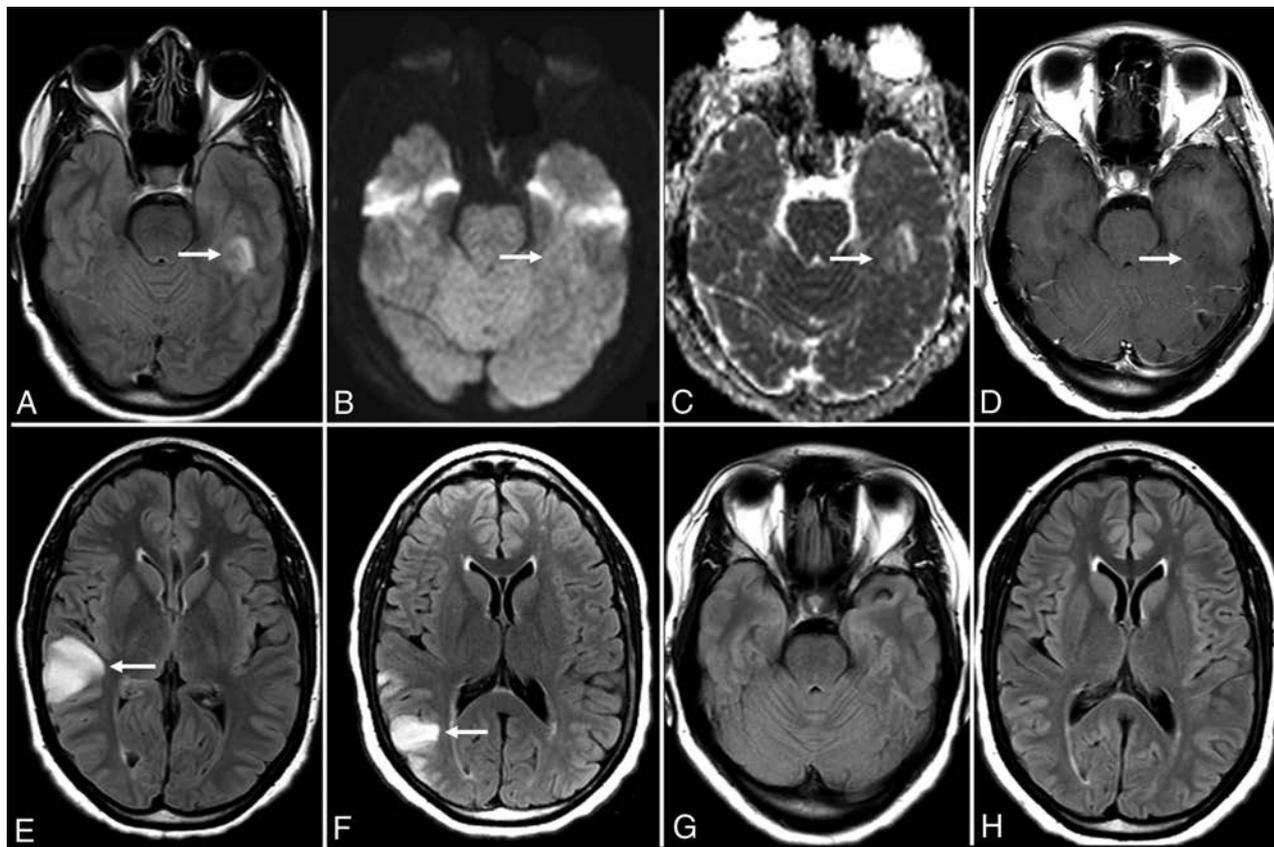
Hashimoto encephalitis. A 41-year-old woman presented with gradually worsening headaches and memory impairment without the development of psychosis or seizures. MR imaging of the brain (time, 0) demonstrates T2-FLAIR hyperintensity in the inferior left temporal lobe (A) without evidence of restricted diffusion (B and C). MR imaging of the brain (time, 21 days) demonstrates enlargement of the lesion on T2-FLAIR (not shown) without postcontrast enhancement (D). MR imaging of the brain (time, 3 months) demonstrates resolution of the prior lesion (not shown) but development of similar T2-FLAIR hyperintensity in the right frontoparietal junction (E). A subsequent scan at approximately 5 months shows near-complete resolution of that lesion with a new T2-FLAIR hyperintense lesion more posteriorly (F). A follow-up scan (G and H) nearly 1 year from onset shows complete resolution of the imaging abnormalities.
